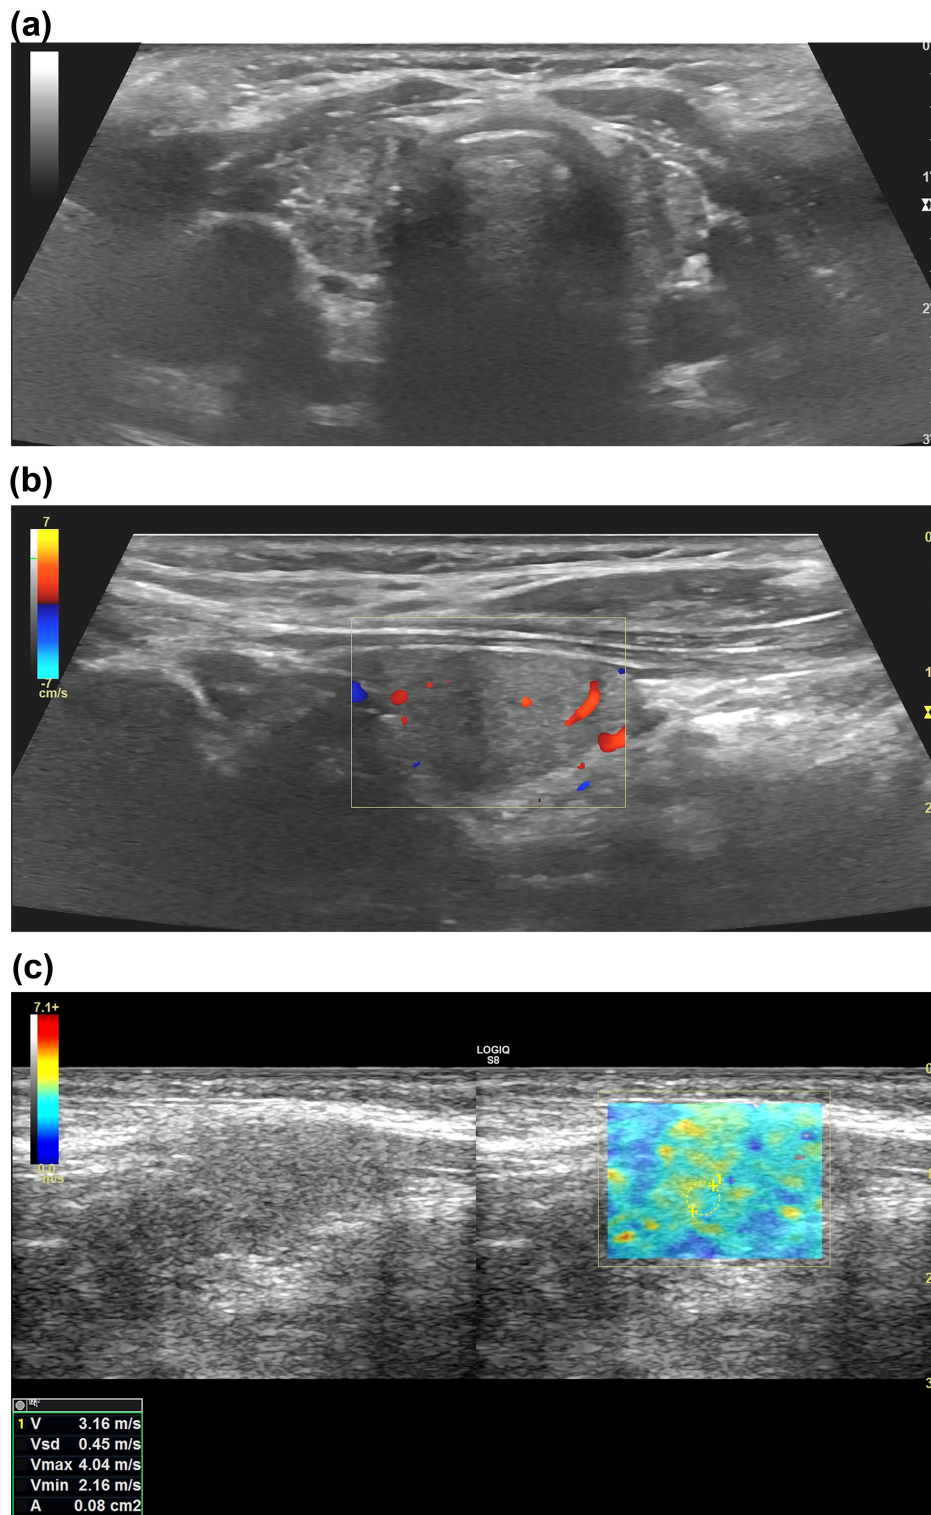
(A) In a case with a diagnosis of chronic autoimmune thyroiditis, decreased thyroid gland volume, contour lobulation, and parenchymal heterogeneity, (B) decreased parenchymal blood supply in color Doppler sonography, and (C) heterogeneous color coding with intermediate stiffness in the parenchyma in shear wave elastography evaluation are seen.
